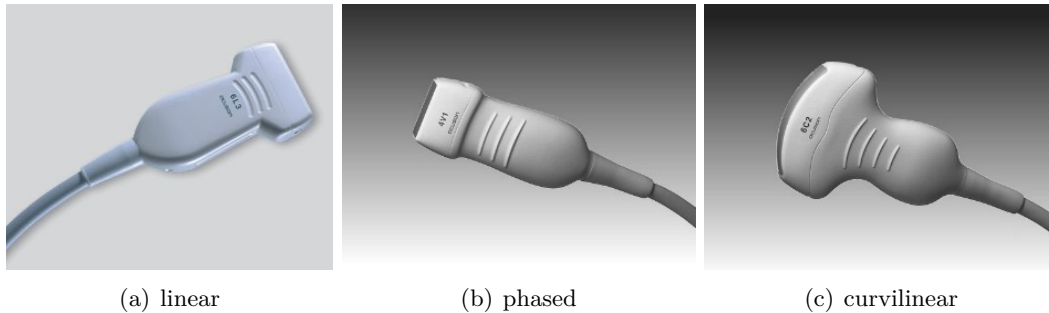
Different 2D ultrasound transducer types.
